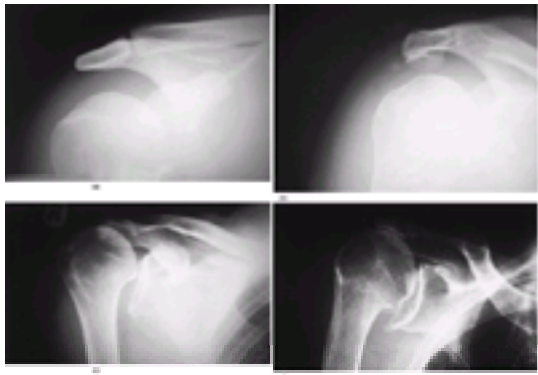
(a) A radiograph of the subacromial space showing a normal appearance of the undersurface of the acromion and acromioclavicular joint. (b) Demonstrating formation of anterior osteophytes on the undersurface of the acromion. (c) With loss of the rotator cuff muscles the humeral head subluxes superiorly causing abnormal articulation of the glenohumeral joint and physical contact between the humerus and the undersurface of the acromion. (d) If superior subluxation of the glenohumeral joint persists then arthritis may develop in the glenohumeral joint. This is known as cuff tear arthropathy.
